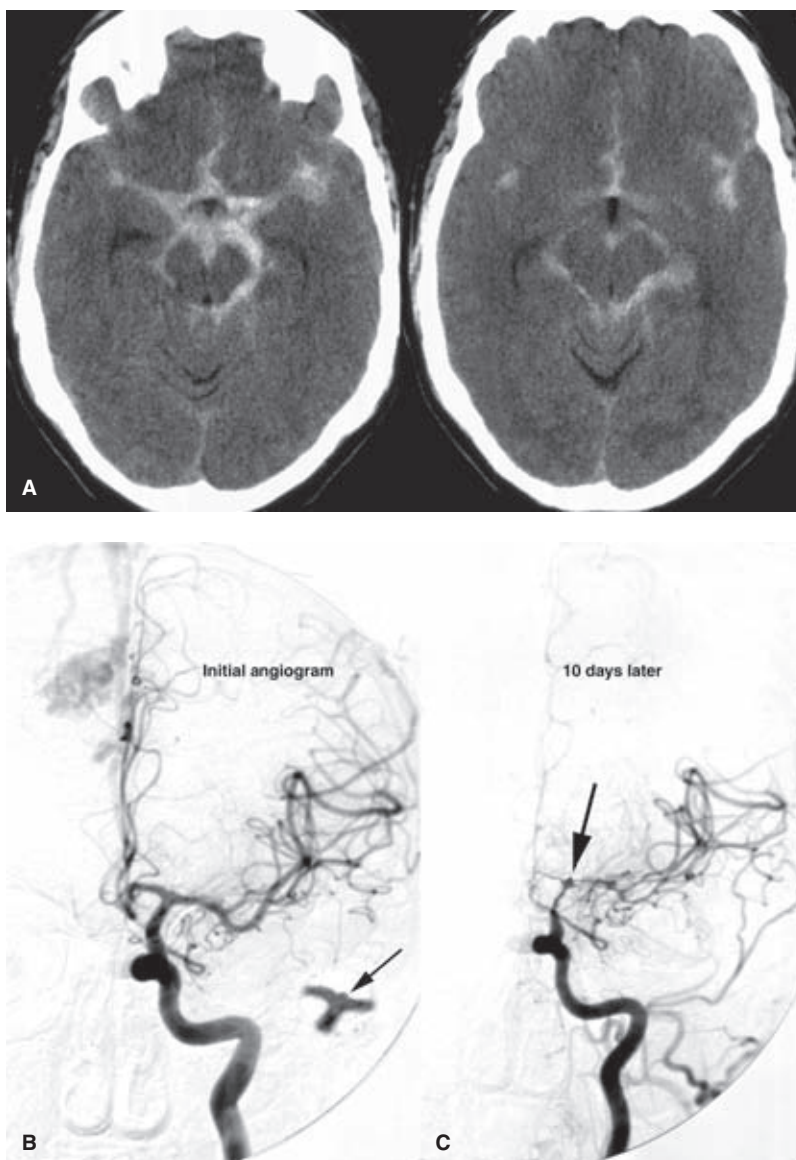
(A–C) Angiographically negative subarachnoid hemorrhage: importance of obliqued and skewed views. A CT examination (A) in an elderly female with Grade III subarachnoid hemorrhage demonstrates profuse subarachnoid hemorrhage and hydrocephalus. The initial angiogram (B) of the left internal carotid artery was interpreted as negative (*inset of subtracted image of left internal carotid artery siphon*). A follow-up angiogram showed an identical appearance on the first lateral view. A skewed view (C) of the left siphon demonstrated the aneurysm (*arrow*). On the magnified *inset*, a waist-like constriction of the aneurysm probably represents where this subarachnoid aneurysm enters the dura of the cavernous sinus. This aneurysm could not be seen on any PA or shallow oblique views because of its position directly behind the genu. Looking for a widening of the diameter of the genu (apparent on the initial lateral angiogram) can help to direct one to the presence of such an occult aneurysm. Because this aneurysm extends from the subarachnoid space to the extradural cavernous sinus, the term *transitional aneurysm* might be invoked. However, transitional aneurysms usually start on the cavernous segment and expand in the other direction. This case predates the availability of 3D rotational angiography which would have certainly demonstrated a hidden lesion of this nature and location. A low threshold for performing 3D rotational angiography in the work-up of occult SAH is a good policy.
